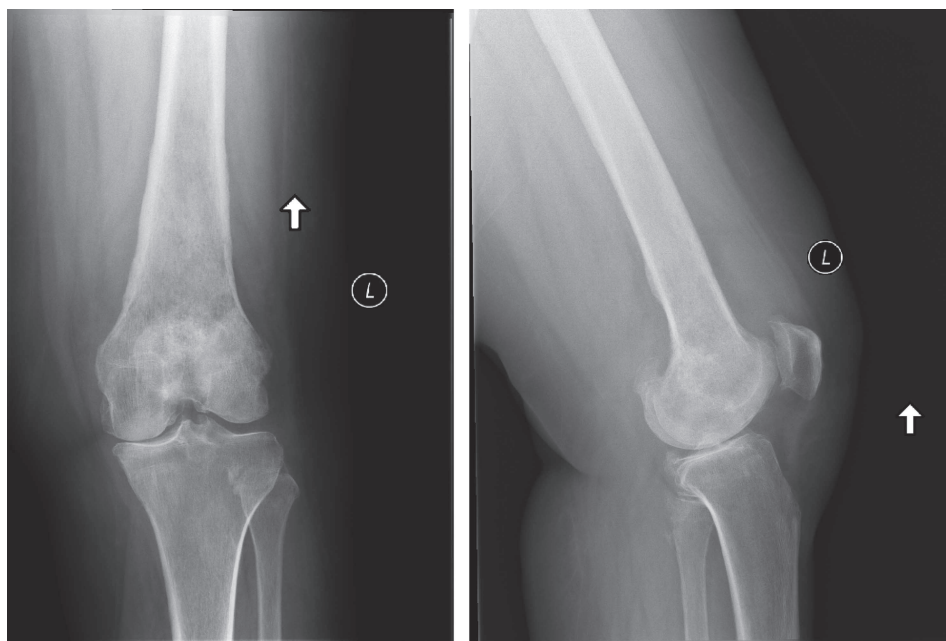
Anteroposterior and lateral radiographs of the left knee. Note the mottled and permeative appearance of the distal femur. There is also severe medial joint space narrowing with osteophyte formation medial, posterior, and within the patellofemoral joint.
